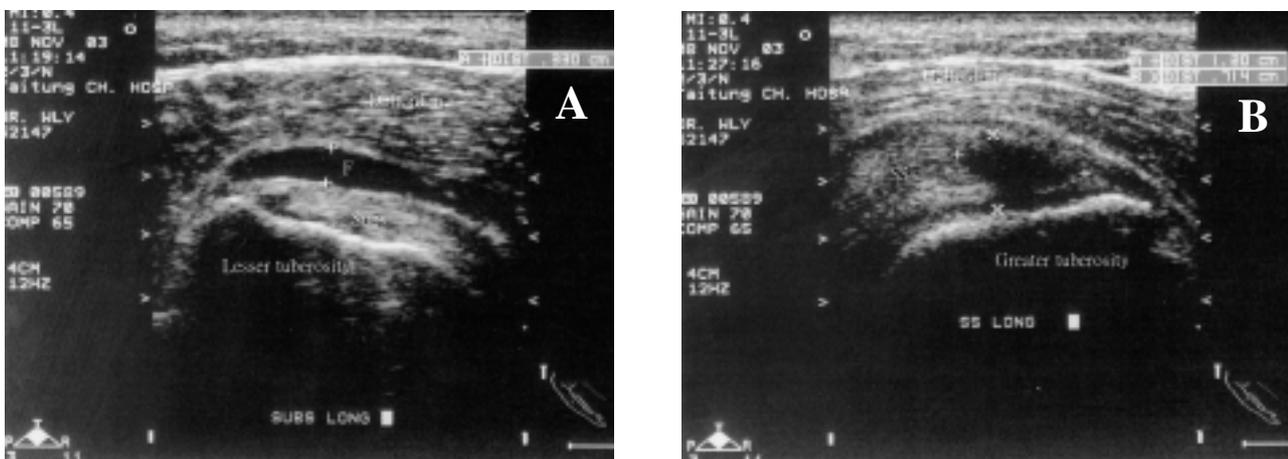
Ultrasonography of shoulder impingement syndrome (patient 11). (A) Fluid (F) collection in the subacromial-subdeltoid bursae overlying the subscapularis tendon (Subs) on a longitudinal scan. (B) Hypoechoic thickening with an anechoic gap (between the calipers) in the supraspinatus tendon (SS) on a longitudinal scan, representing a full-thickness tear.
